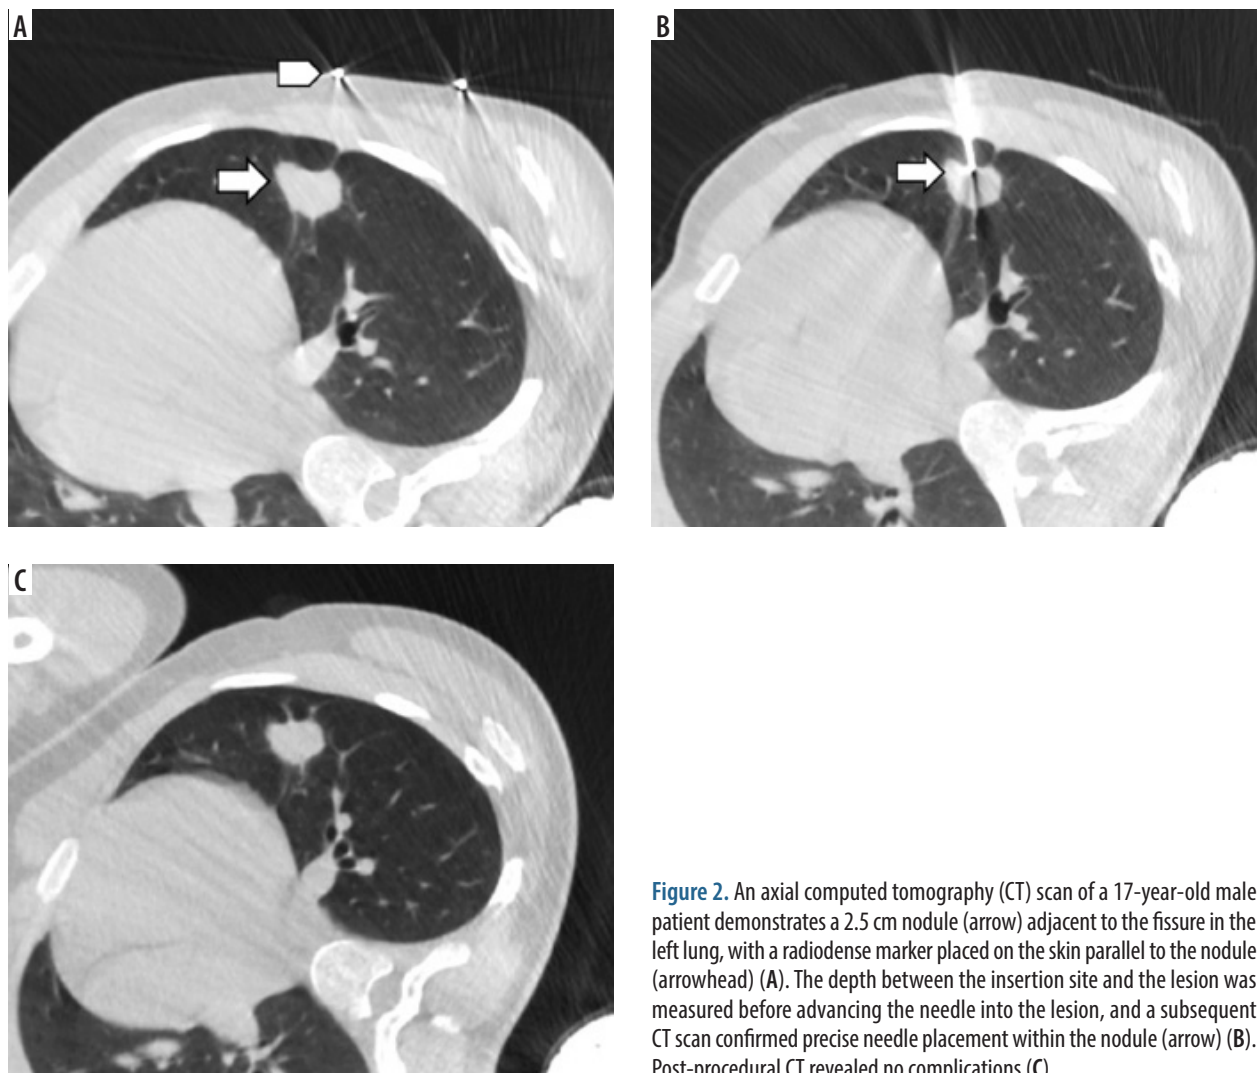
An axial computed tomography (CT) scan of a 17-year-old male patient demonstrates a 2.5 cm nodule (arrow) adjacent to the fissure in the left lung, with a radiodense marker placed on the skin parallel to the nodule (arrowhead) (A). The depth between the insertion site and the lesion was measured before advancing the needle into the lesion, and a subsequent CT scan confirmed precise needle placement within the nodule (arrow) (B). Post-procedural CT revealed no complications (C)
